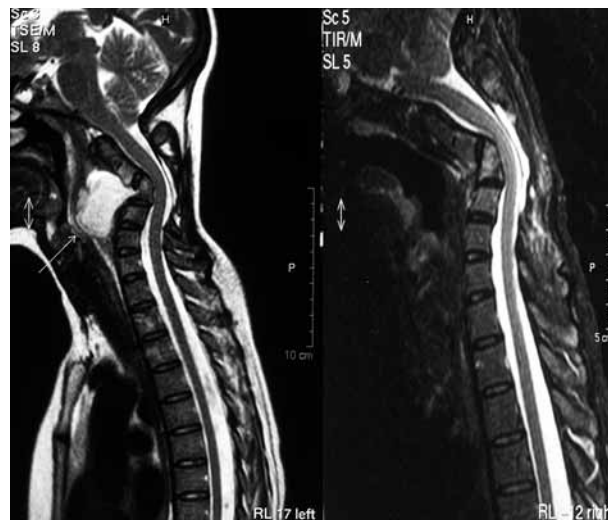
T2 weighted sagittal MRI scan of the neck (left) 7 weeks after initial presentation, showing a huge anterior prevertebral abscess compressing on the oesophagus, causing dysphagia. Also, note the communication with the C3 vertebral body indicating the anterior cortex of the bone was breached, leading to discharge of the purulent material into the prevertebral space. The MRI scan (right) after CT guided aspiration and 3 months of treatment with halo vest immobilisation and antibiotic treatment showing complete resolution of the abscess.
